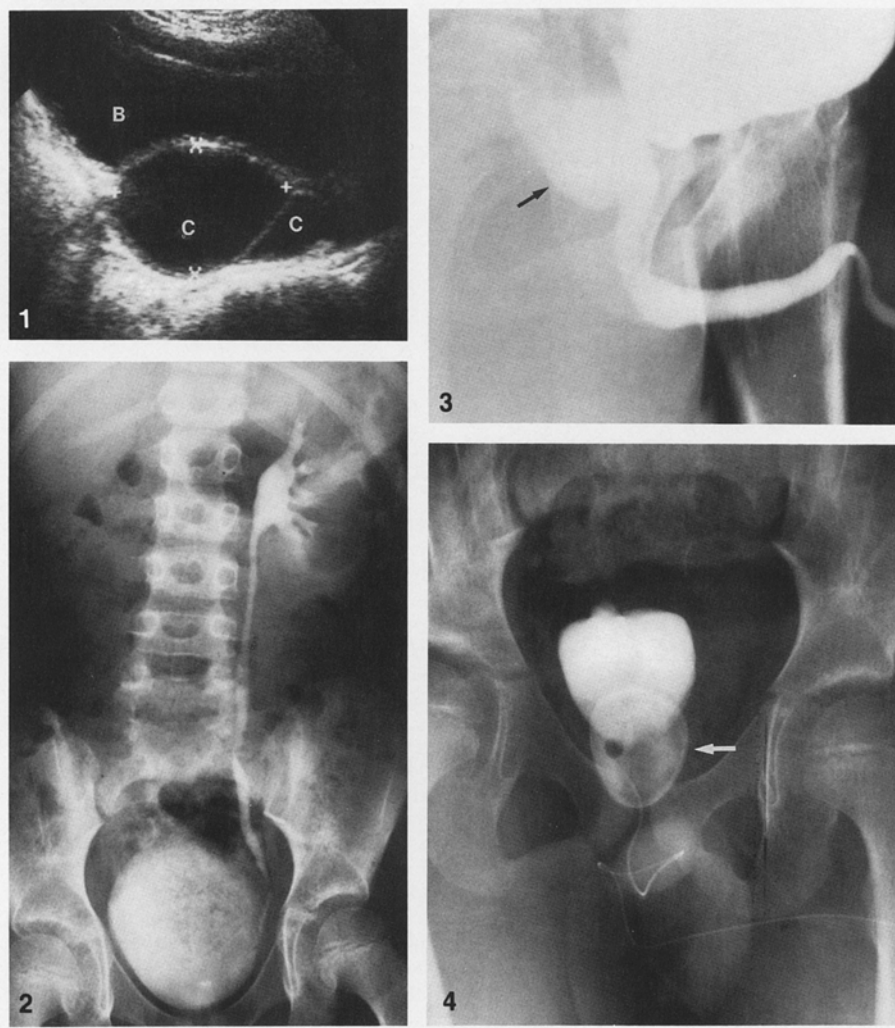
Sagittal view from a sonogram of the pelvis showing two cystic lesions (C) lying posterior to the bladder (B).
